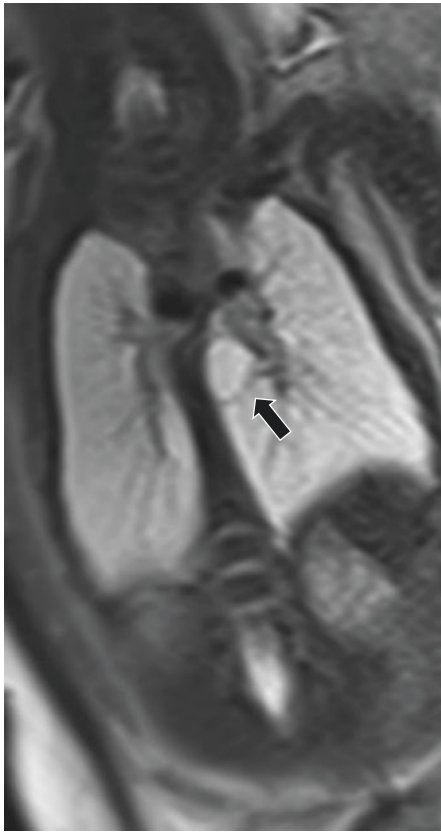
Bronchogenic cyst on prenatal MR imaging. Coronal non-enhanced T2-weighted image shows a thin-walled cyst (*arrow*) adjacent to the left bronchus
